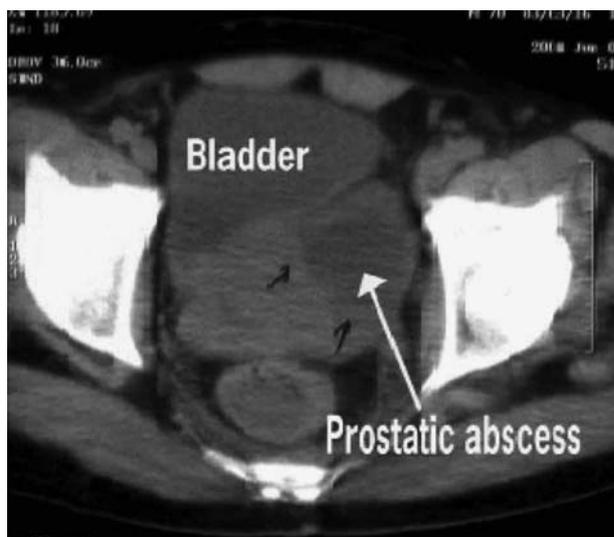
Computed tomography scan shows a homogenous mass with low density in the left prostatic lobe.
